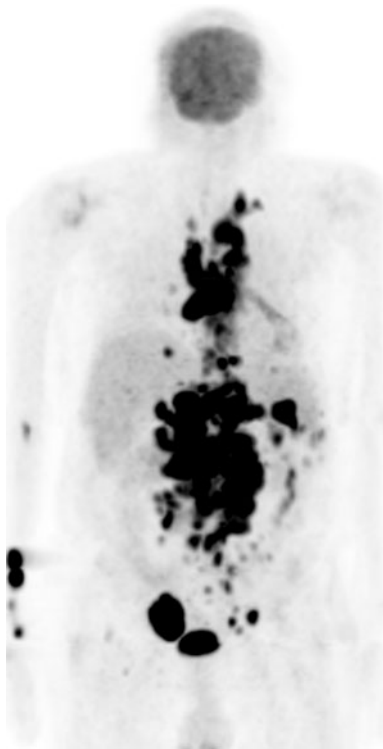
NHL in a 50-year-old man with AIDS and progression of lymphadenopathy. Maximum intensity projection imaging of the whole-body FDG PET shows extensive bulky mediastinal and retroperitoneal nodes with intense uptake (SUV 20). Biopsy of mediastinal nodes suggested NHL. Large, conglomerate FDG avid nodal lesions are often indicative of a neoplastic rather than infectious/inflammatory process
